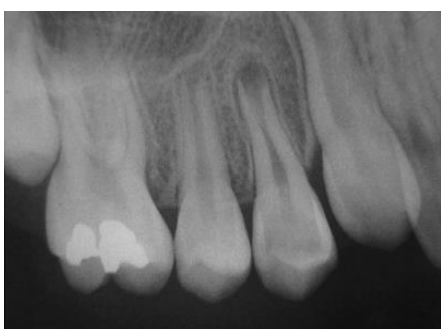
Initial radiograph of the tooth
